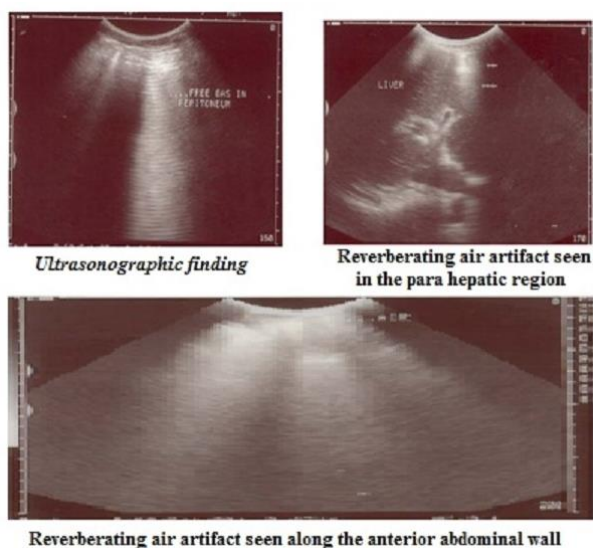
Ultrasonography.
